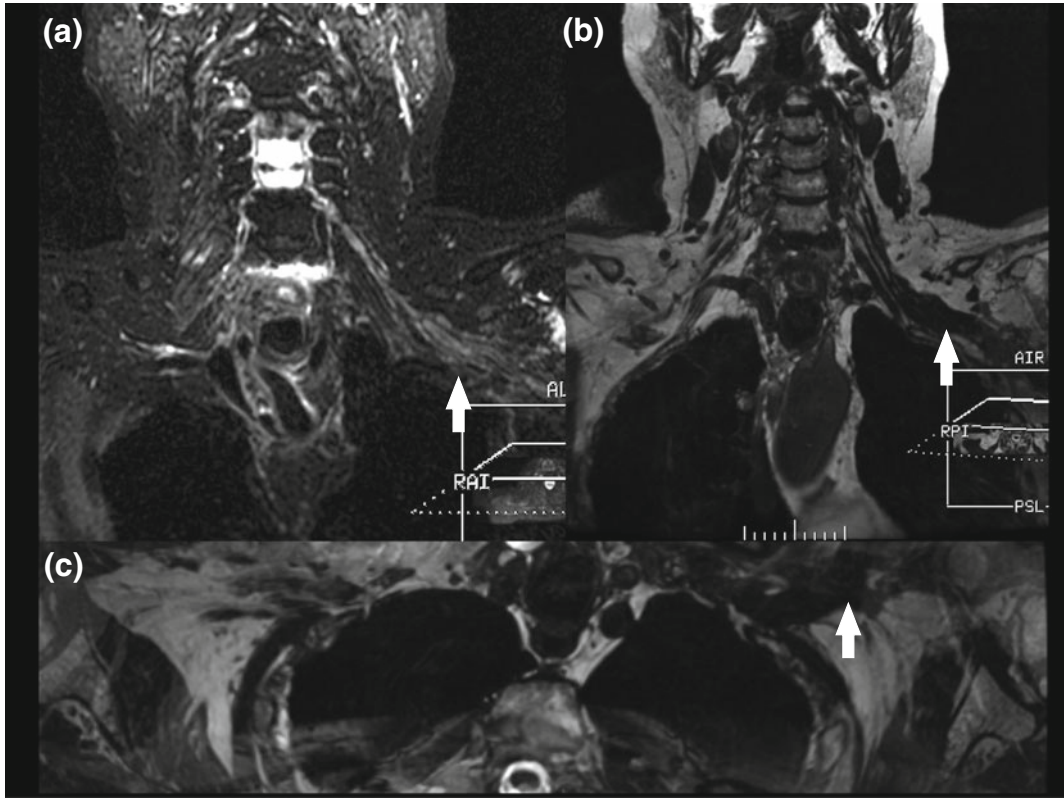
Radiation neuropathy: brachial MR neurography in a 75 year old female with background of radiation due *left* breast cancer since 15 years ago. Sequence 3D IDEAL coronal FAT SAT T2-weighted image (a), 3D
